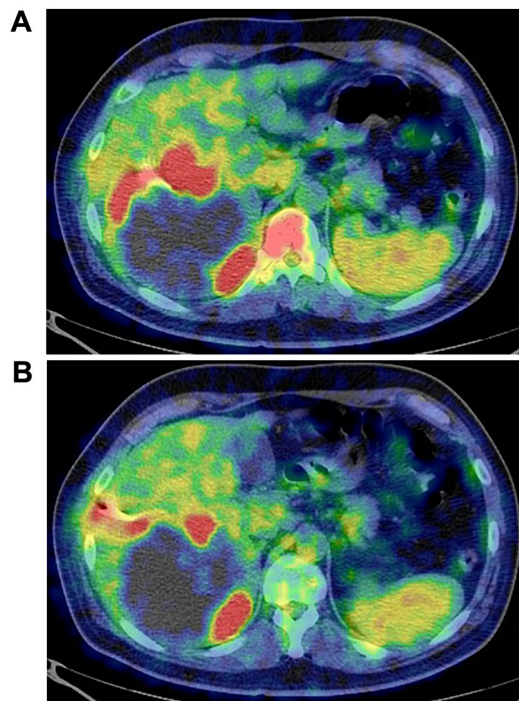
Positron emission tomography showed a hypermetabolic lesion in the area surrounding the tumor (A), and a strong signal was also observed along the PTAD tube (B) (SUV_{max}: 4.80).
